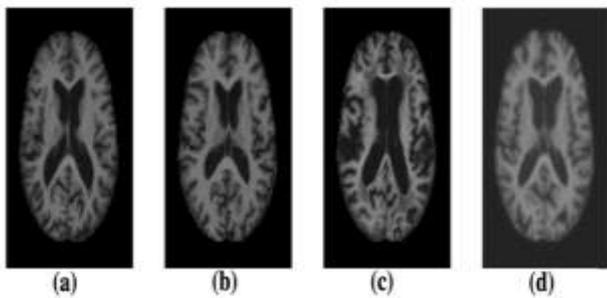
Sample of various brain MRI images with various AD stages. a Non-demented; b Very mild dementia; c Mild dementia; d Moderate dementia.
